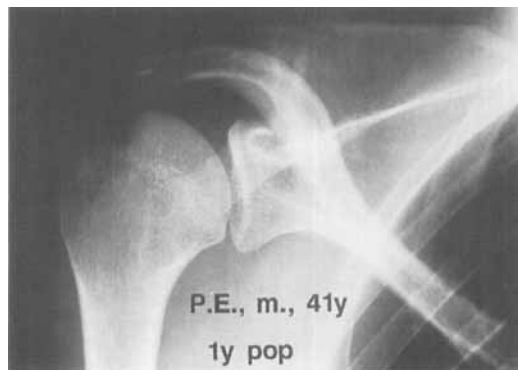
1 year postoperatively and 6 months after removal of the lag screw: the anteroposterior radiograph with a 30° caudal tilt of the beam and the axial radiograph show bony healing of the pseudarthrosis and applanation of the hypertrophied callus.
